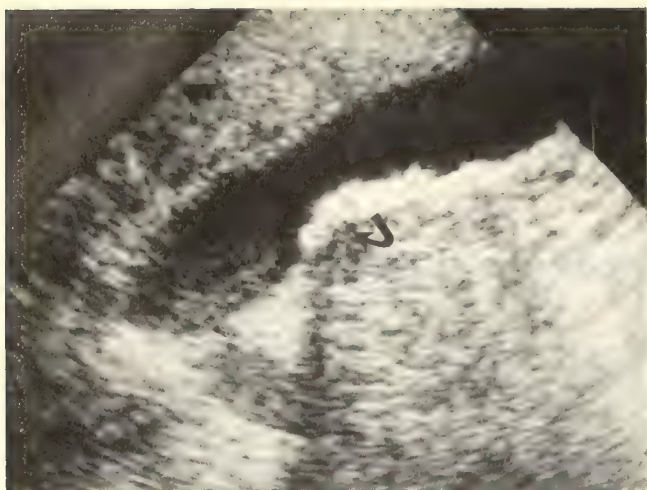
Sagittal ultrasound of gallbladder demonstrating numerous echogenic foci with shadowing (arrow) compatible with gallstones.
